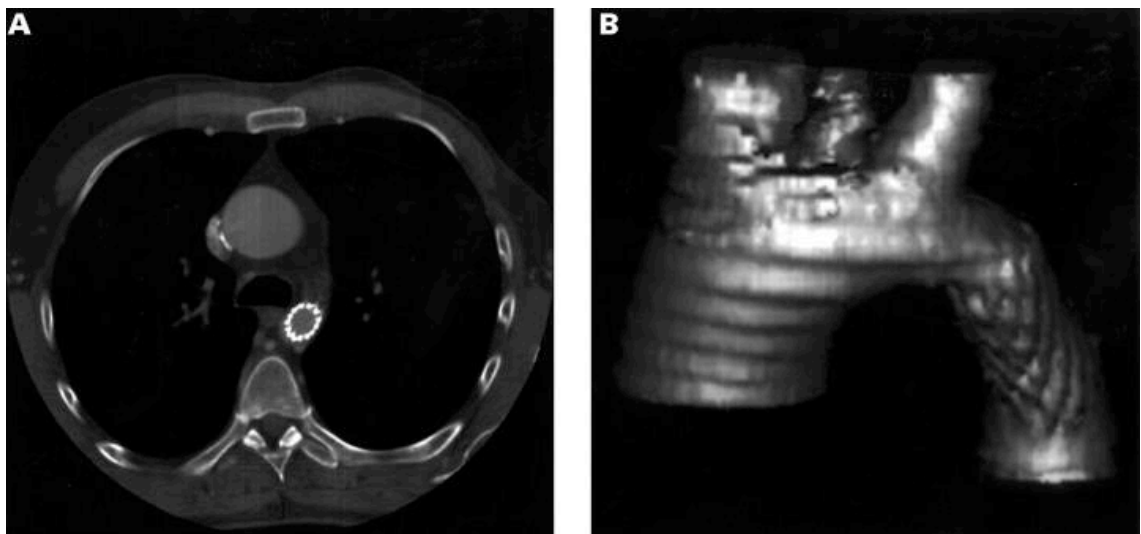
(A) Follow up spiral computed tomography (CT) with contrast showing stented aorta in cross section.(B) Axial three dimensional reconstruction of CT images in the same patient showing no evidence of aneurysm formation.
